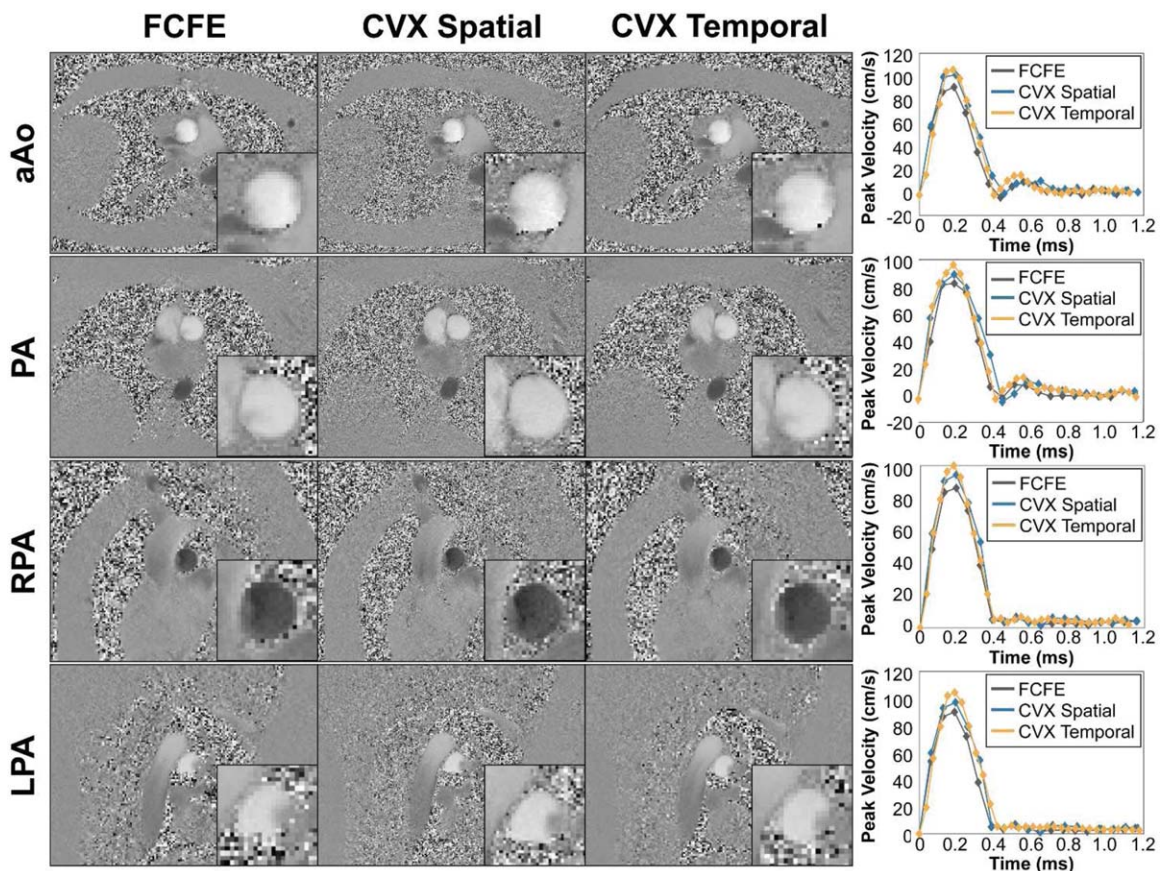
Representative PC-MRI images and measured peak velocity profiles within the ascending aorta (aAo), main pulmonary artery (PA), right pulmonary artery (RPA), and left pulmonary artery (LPA) from a single volunteer for the FCFE and CVX sequences.
